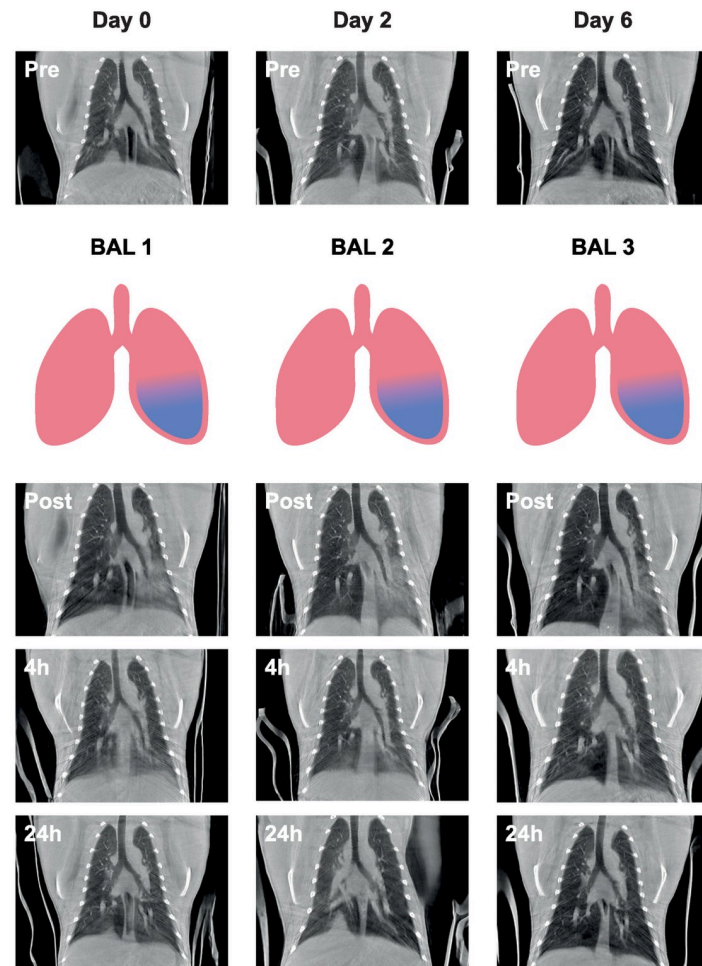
Representative coronal slices (of RM2) of all CTs obtained during the three BALs. The procedures are represented in a vertical manner whereas the time in days is represented horizontally. The procedure starts with a pre-BAL CT (Pre), followed by a left-sided (blue) BAL 1, a post-BAL CT (Post) and a four hour post-BAL CT (4h) on Day 0. The next day, Day 1, the 24 hour post-BAL CT (24h) was obtained. The procedures for BAL 2 and BAL 3 were performed in a similar order.
